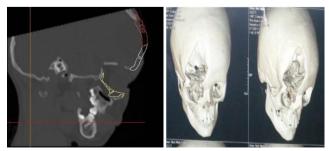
Preoperative CT of the brain showing Orbital defect
